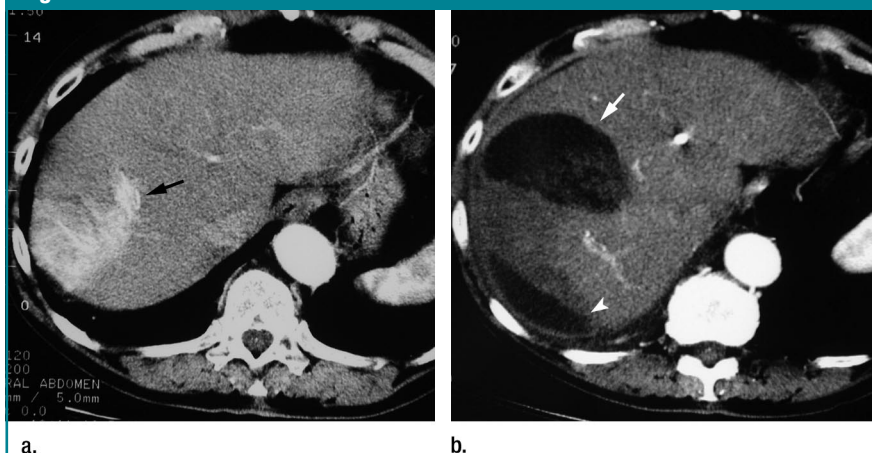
Transverse CT scans in arterial phase show complete ablation of large infiltrative HCC invading the segmental portal vein in 82-year-old man with Child-Pugh class A cirrhosis related to alcohol abuse. (a) Scan obtained before treatment shows infiltrative 6.3-cm hypervascular mass (arrow) in segment VIII of the liver that invades the segmental portal vein. (b) On scan obtained one month after multipolar RF treatment consisting of two procedures, including three applications (total amount of RF energy delivered, 435 kJ), the mass, including the intravascular invasion, no longer enhances. The α -fetoprotein serum level decreased from 1330 to 4 $\mu\text{g/L}$, confirming the imaging results consistent with complete ablation. Note also the segmental infarct of liver (arrow) and the presence of a small posterior subcapsular fluid collection (arrowhead).
